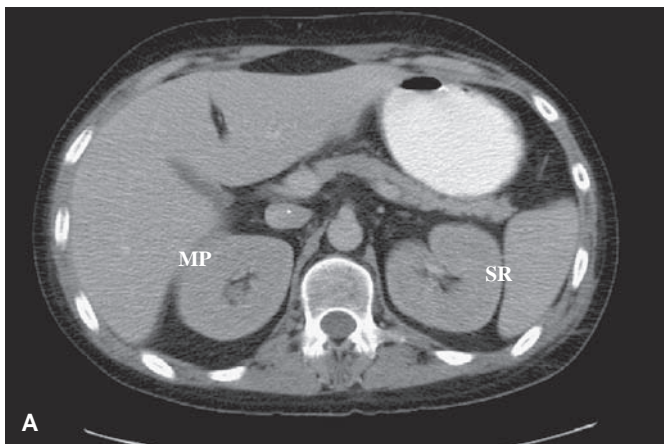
A: Computed tomography cross-sectional view of abdominal anatomy. Note the dependent areas of Morison's pouch (MP) and the splenorenal recess (SR). B: Pelvic anatomy. Note the dependent rectovesical pouch (RP) between the posterior wall of the bladder and stool-filled rectum.
